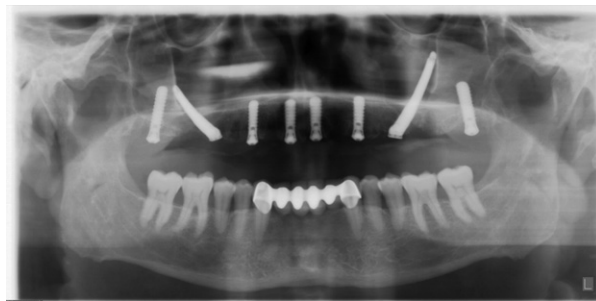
Case 6. Extraoral panoramic x-ray view after dental implant placement: 4 in the anterior sector, 2 trans-zygomatic implants, and 2 pterygoid implants.
